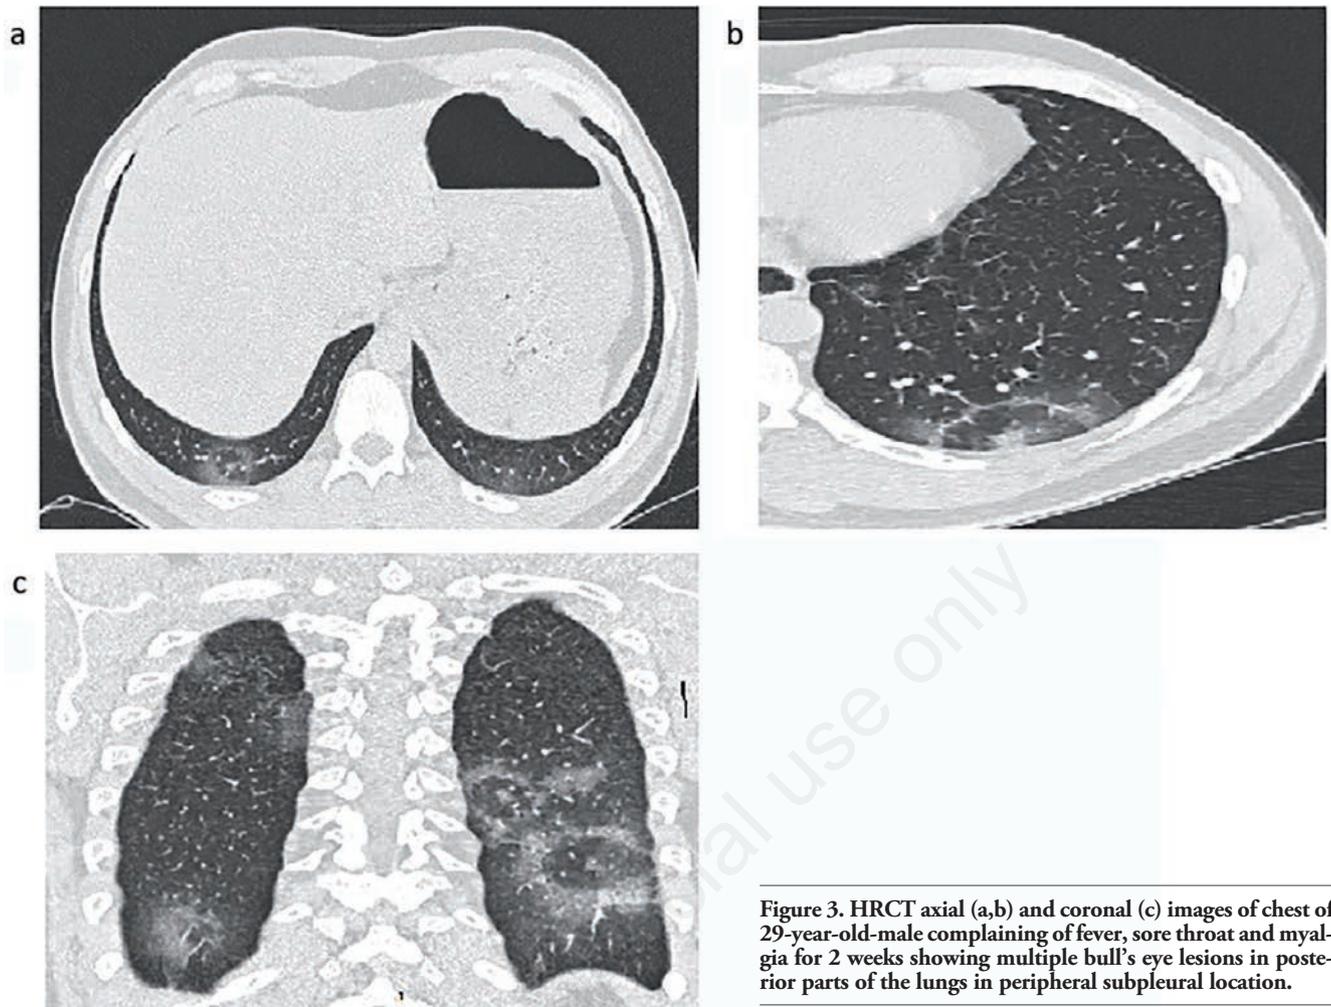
HRCT axial (a,b) and coronal (c) images of chest of 29-year-old-male complaining of fever, sore throat and myalgia for 2 weeks showing multiple bull's eye lesions in posterior parts of the lungs in peripheral subpleural location.
